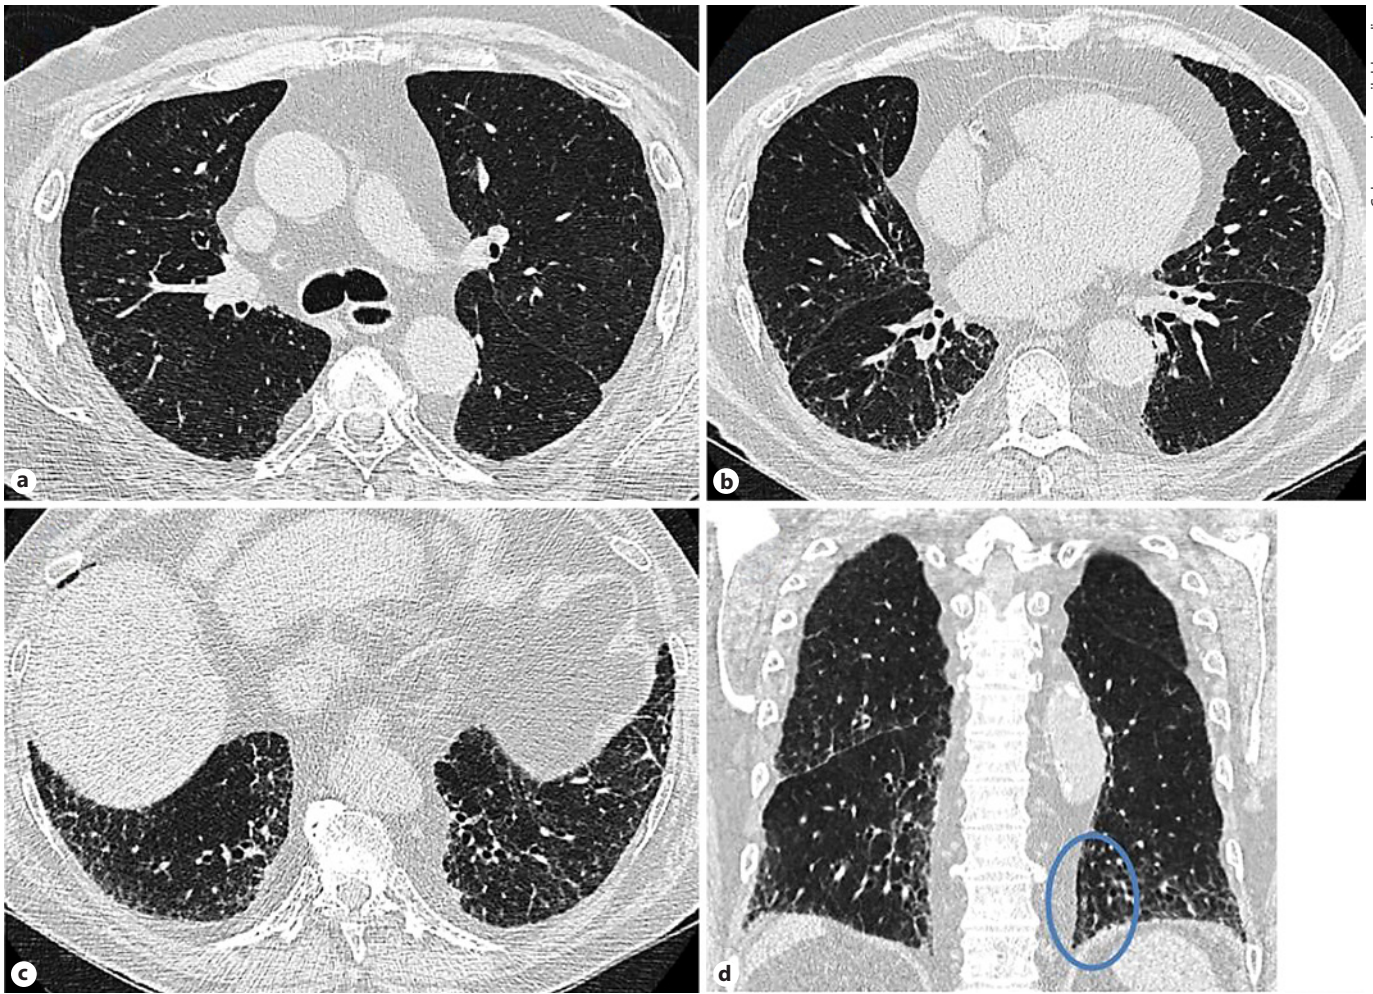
Probable UIP pattern on HRCT: (a–d) the CT images show increased basal-predominant subpleural reticulation with peripheral traction bronchiectasis (circle in d) but without honeycombing.
